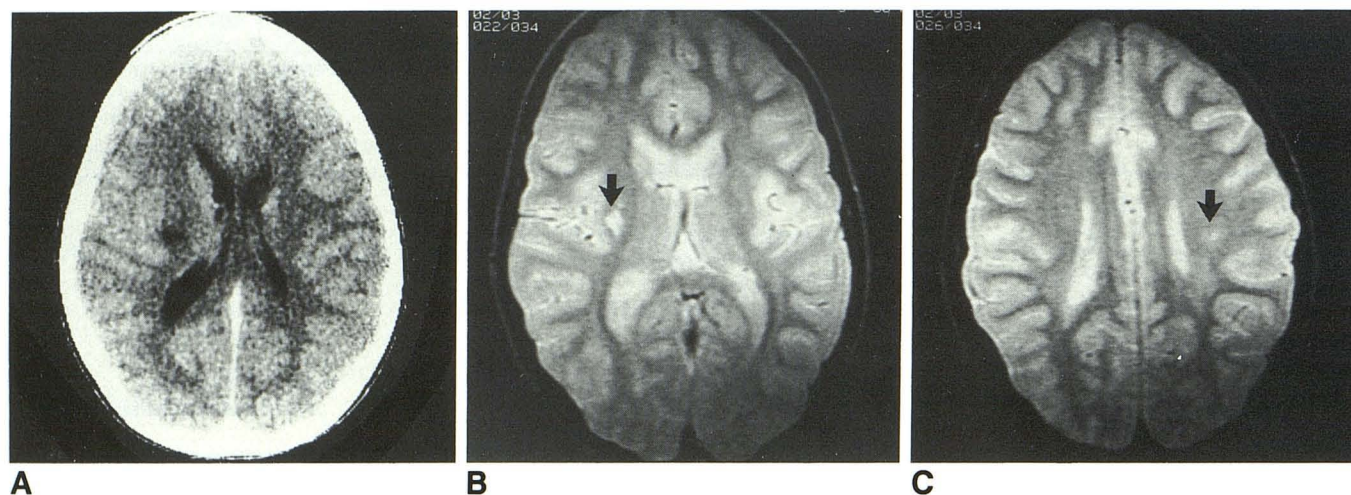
A, Focal hypodensity in right corona radiata on enhanced CT scan in 13-year-old boy who presented with tick paralysis is consistent with demyelination.
